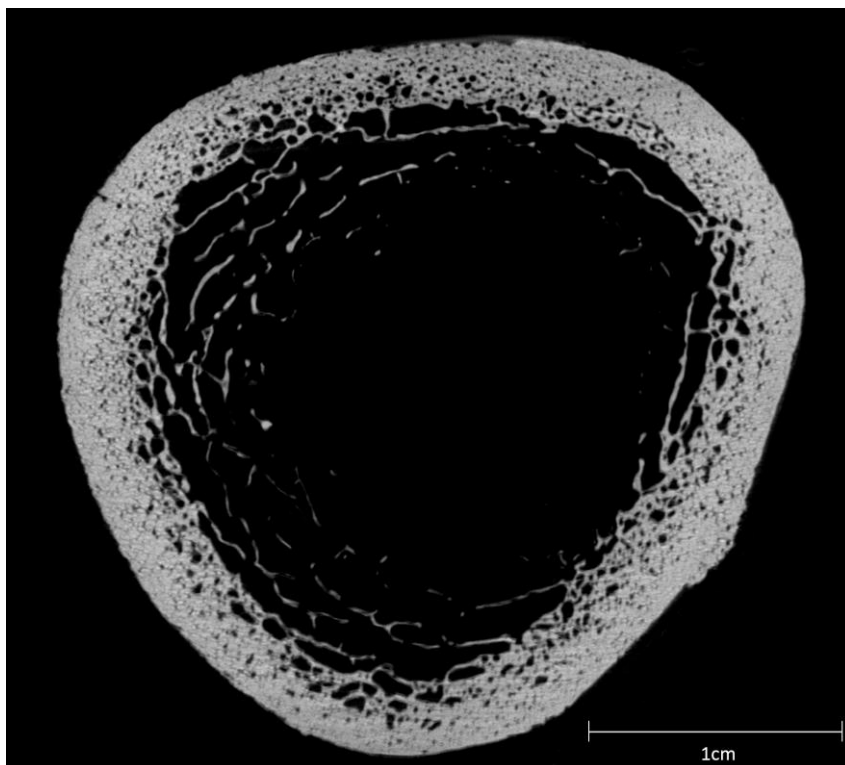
Orthoslice of experimental sample demonstrating results from post current application μ CT
